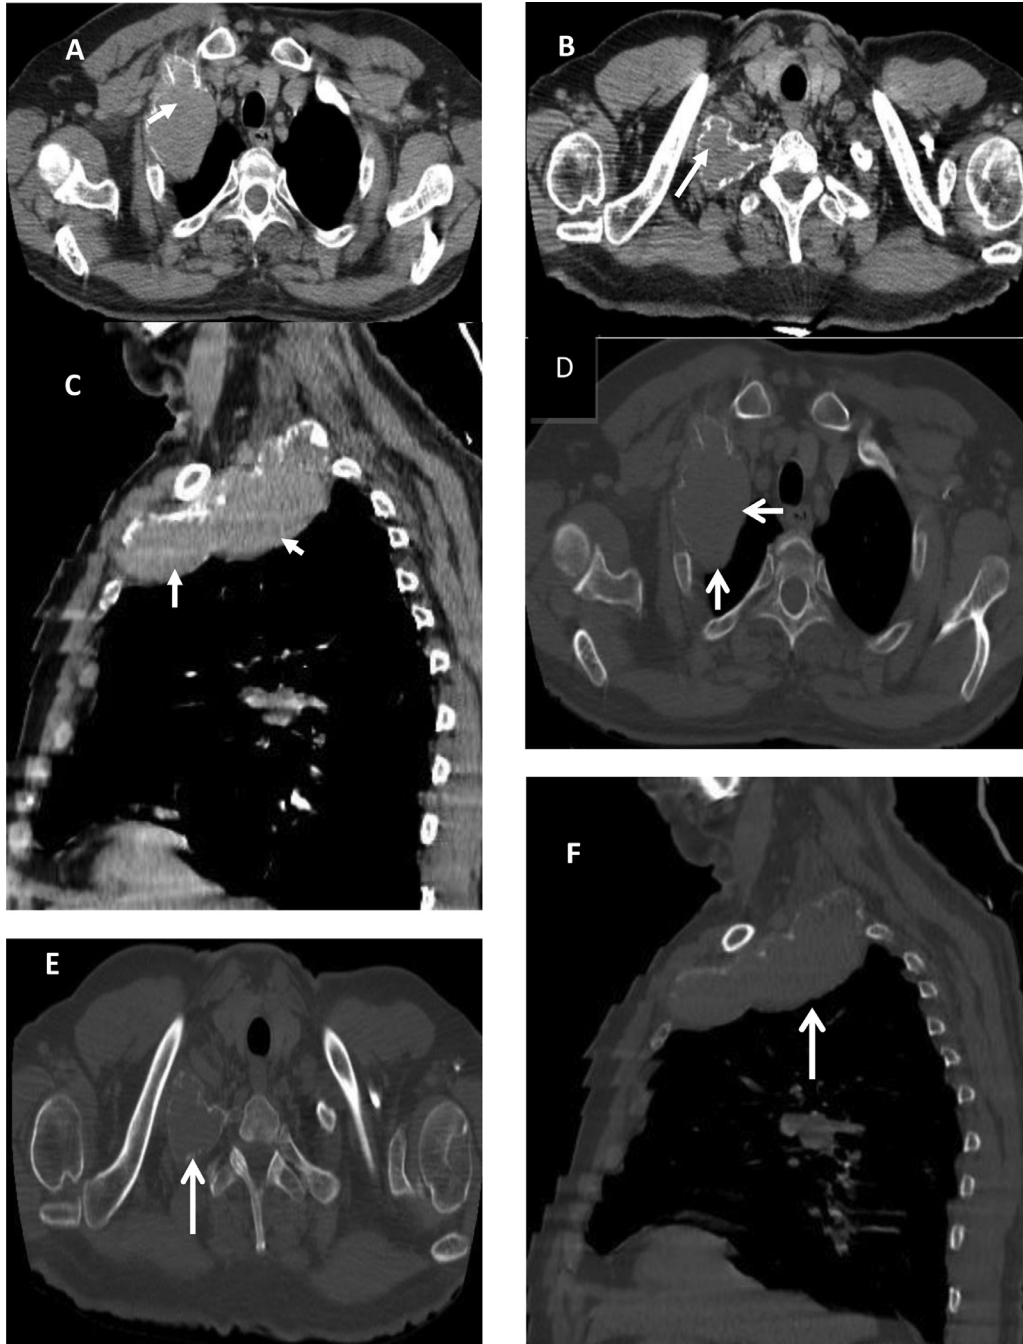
Contrast-enhanced computed tomographic scan chest in the mediastinal parenchyma window, in axial section and sagittal reformatted scan (A-C), and the bone window in axial section and sagittal reformatted scan (D-F), all showing a mass of tissue with a large zone of osteolysis of the right first rib without intrinsic calcification or infiltration of the chest wall (white arrows). No associated mediastinal lymphadenopathy or intrapulmonary infiltration was evident.
